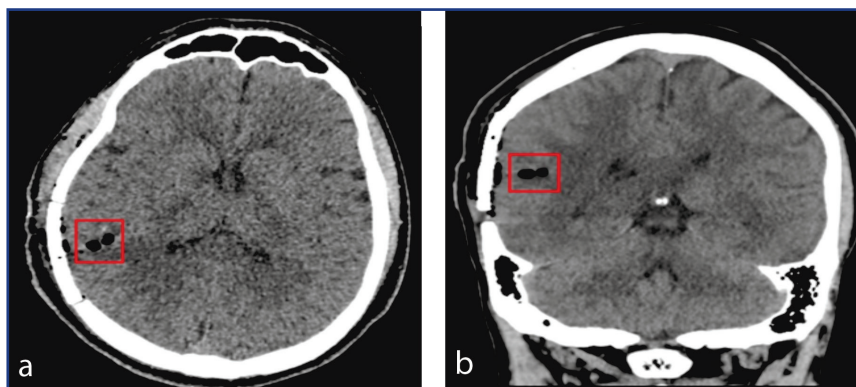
A postoperative brain CT: a – axial projection, b – frontal projection
